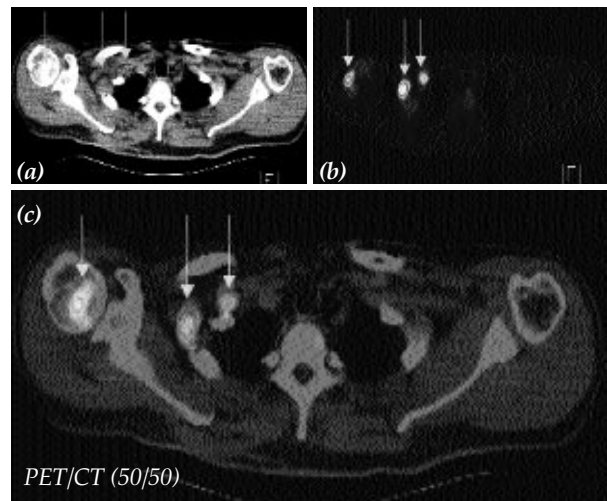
Malignant melanoma with lymph node metastasis. Bone metastasis is only visualized by PET. Patient 58-y, m, SSM, 4.3 mm, right shoulder, re-staging (3-y). (a) CT: LN right supraclav. (1.2, 1.5 cm Ø) + right axilla (1.0 cm Ø). (b) PET: 2 foci right supraclav. + right humerus head, axilla neg. (c) PET/CT: image fusion enabled detection of possible corticalis disruption; made further diagnostic procedures dispensable.
